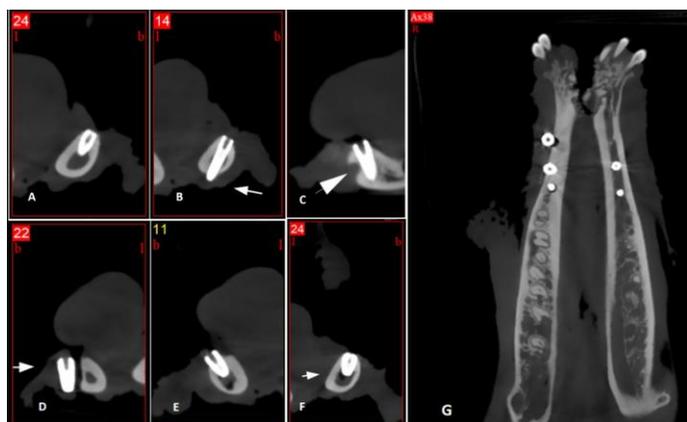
(A-G): Cross-sectional and axial CBCT images of implants. A: Normal placement, B: Cortical perforation, C: Mental foramen perforation, D: Advanced crestal bone loss, E: Crestal bone loss, F: Mandibular canal perforation, G: 0,5 mm axial view.
